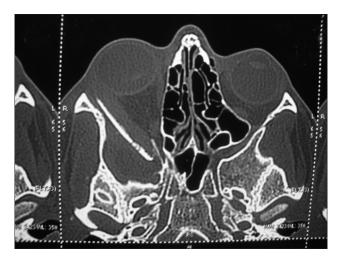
CT axial bonycuts showing graft in place
